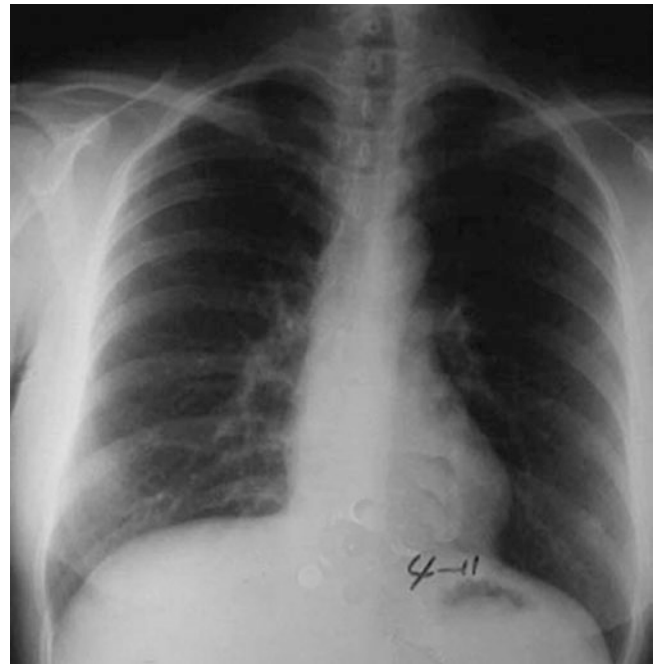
On day 1 of pneumonia, the chest X-ray shows subpleural flakes of blurry shadow at the right lower lung. (Reprinted with permission from Liang [6])
